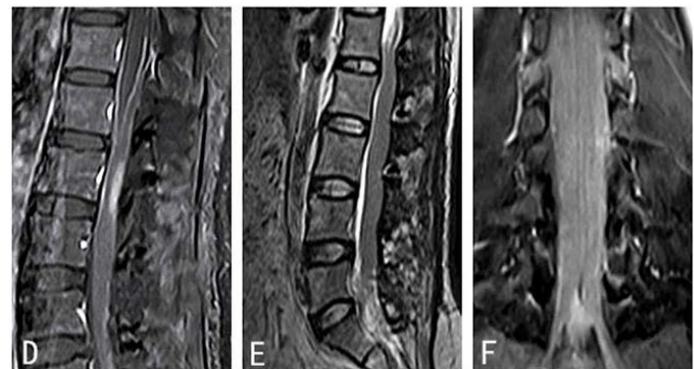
Sagittal T1WI image of enhanced MRI scanning of lumbar vertebrae at one week after surgery. The spinal cord was obviously thinner than before, with abnormally enhanced signals of the focal spinal cord at the L2 level and linear enhancement of the upper dura mater. Sagittal T2WI image and enhanced coronal T1WI image of lumbar MRI scanning at 3 months after surgery. The spinal cord was thickened, and fresh patchy isointense signals were observed in the spinal cord, which showed infiltrative growth. The abnormally enhanced shadow in the spinal cord was enlarged and widened compared to the previous images, and there were unclear structures of the inferior portion of the cone and cauda equina, with uneven enhancement of the local nerve roots.
